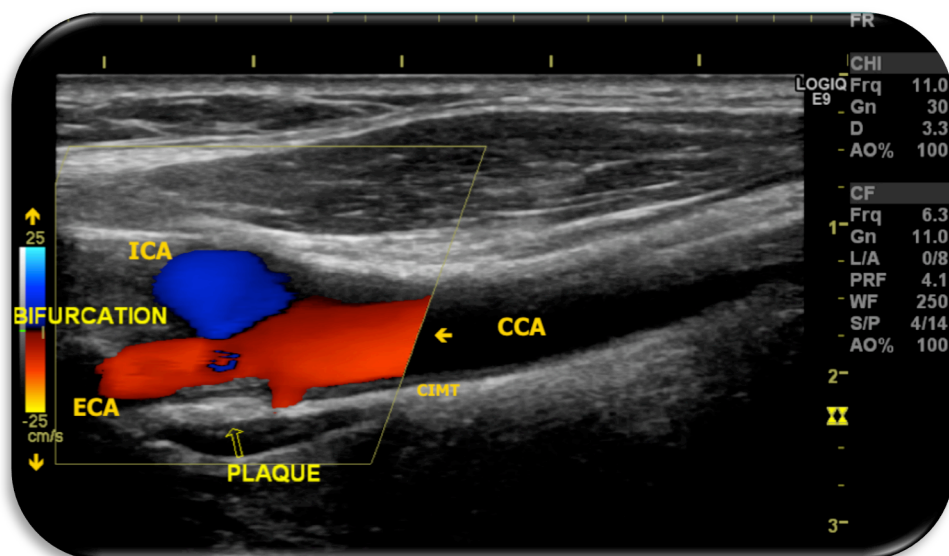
B: Original image of subtle plaque in the carotid bulb using colour Doppler mode.
